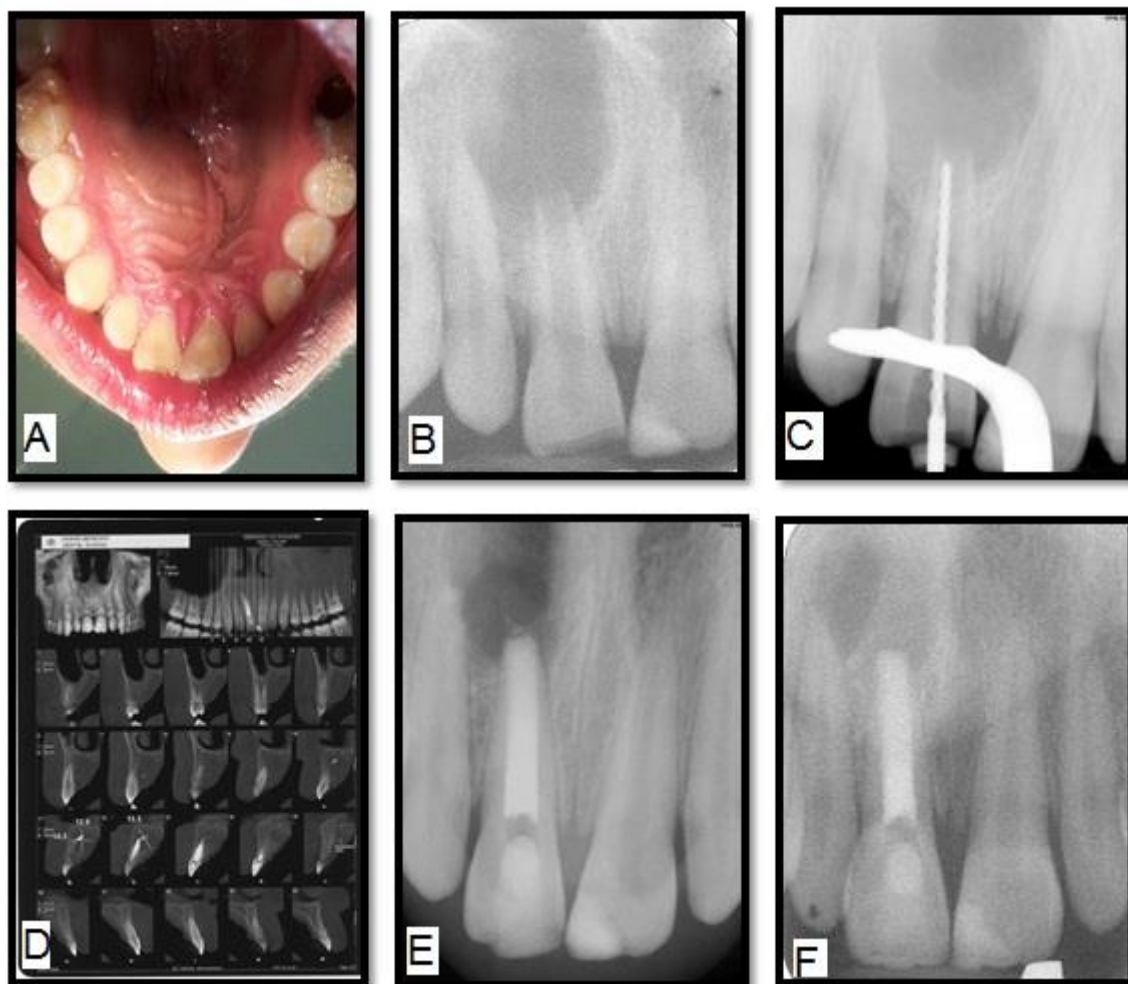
A- swelling in palatal region. B- Preoperative radiography C- working length detection D-Cone Beam Computed tomography before surgery.E- postoperative radiography F- follow up after 12 months
